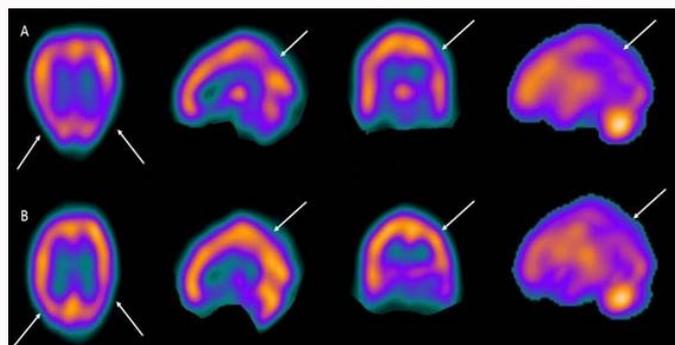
Brain perfusion SPECT (cross-sectional, sagittal, coronal and 3D views) performed after intravenous administration of 1107 MBq of ^{99m}Tc -ECD. A 79-year-old male patient, moderate recent memory disorders, moderate disorientation in time and space, an evolution time of 8 years, and a clinical diagnosis of moderate Alzheimer's disease. Computed Axial Tomography did not report alterations. A) Study prior to treatment shows more intense bilateral posterior temporal-parietal hypoperfusion in the left hemisphere. B) Study one year after treatment (0.5 mg intranasal of NeuroEpo, three times a week) showing increased cerebral perfusion in previously affected regions. Arrows point to regions with changes in perfusion. The changes in perfusion were associated with slight clinical improvement.
